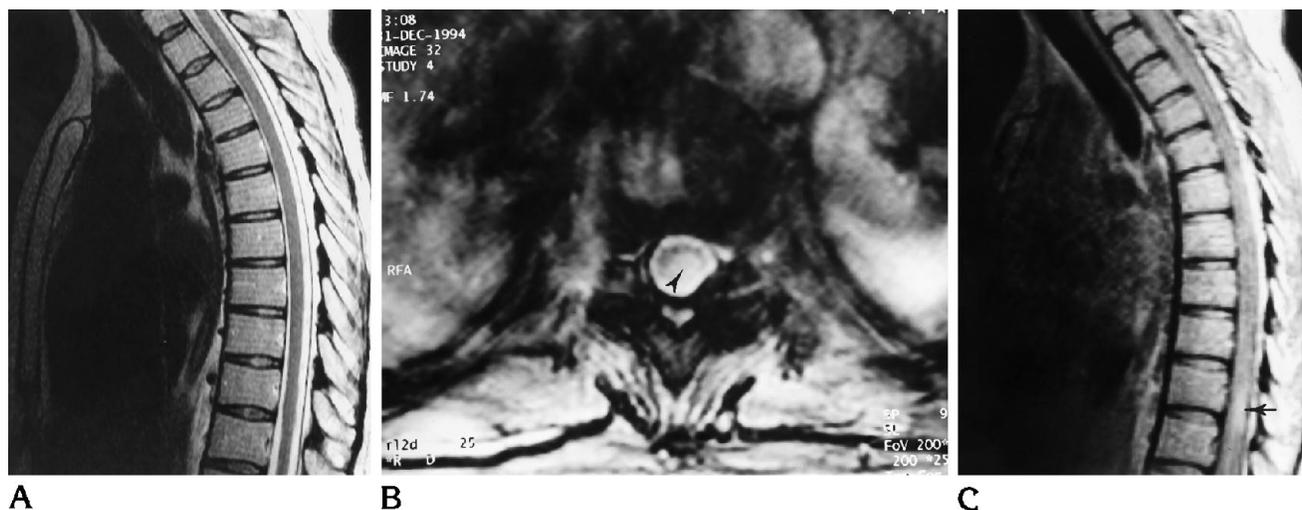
A, In this patient with demyelinating cerebral lesions and suspicion of intramedullary lesion, sagittal T2-weighted FSE MR image (4000/128 [repetition time/echo time]) was normal.
